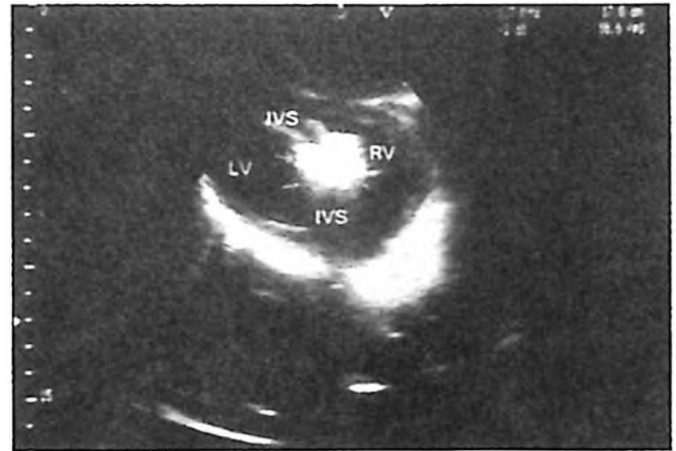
Echocardiographic image of the Amplatzer ventricular septal defect occluder device (indicated with arrows).
